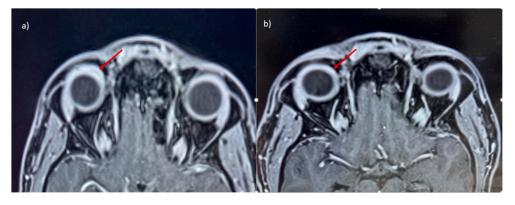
MRI, axial T1W image of the patient shows. a) localised thickening of medial aspect of the right eyeball with localised area of hyporeflectivity suggestive of fluid accumulation within the sclera confirming the diagnosis of anterior nodular scleritis. b) resolution of scleral thickening post treatment.
